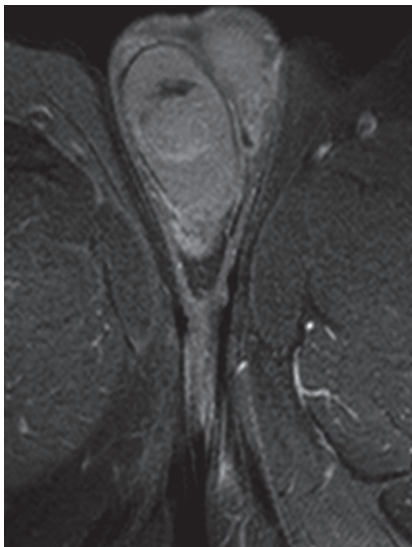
Contrast-enhanced MRI (T1) revealed a round testicular mass approximately 23 mm in diameter with homogeneous enhancement and diffusion restriction.
